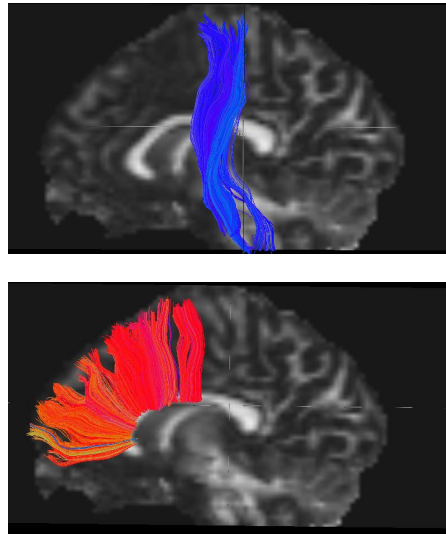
Left Corticospinal tract and part of the Corpus Callosum extracted with WMQL plotted on a MRI volume*
